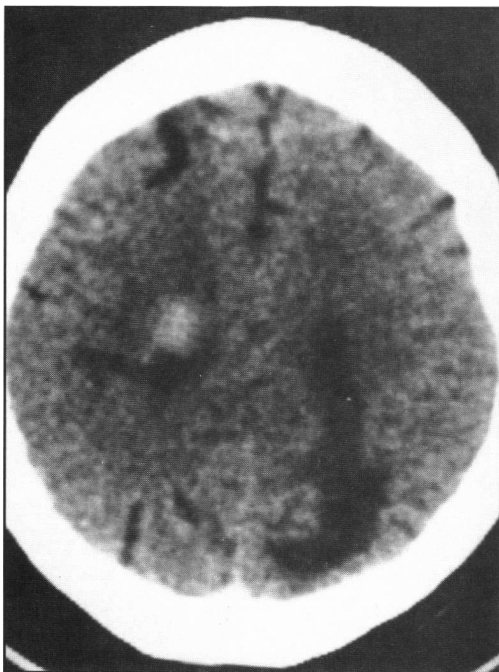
Computed tomogram without contrast showing a hematoma in the right posterior frontal region as well as an area of low density in the left posterior parietal lobe.
